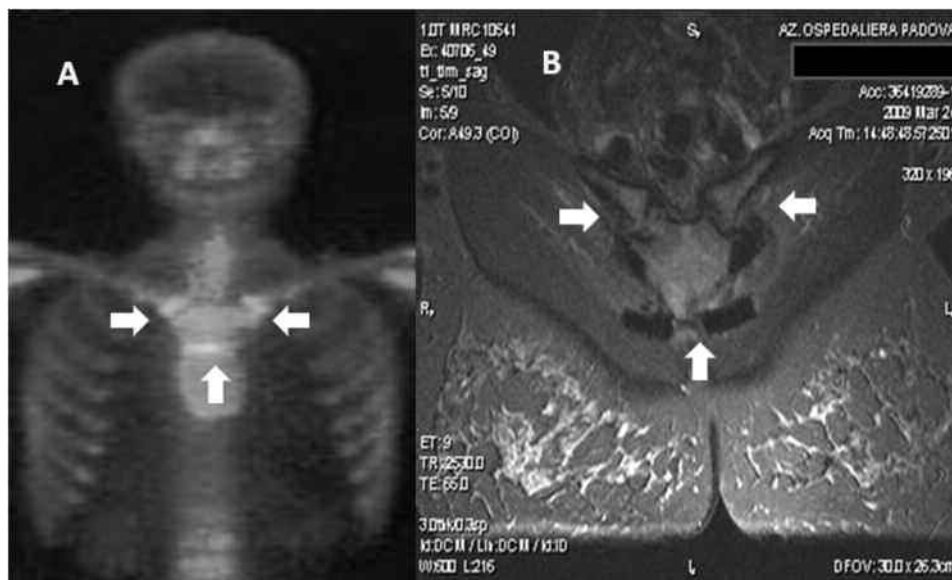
A. Bone scan shows sternocostoclavicular joint (SCCJ) and manubriosternal joint hypercaptation (arrows). B. T2 magnetic resonance imaging sequence shows bone edema of SCCJ (arrows).
